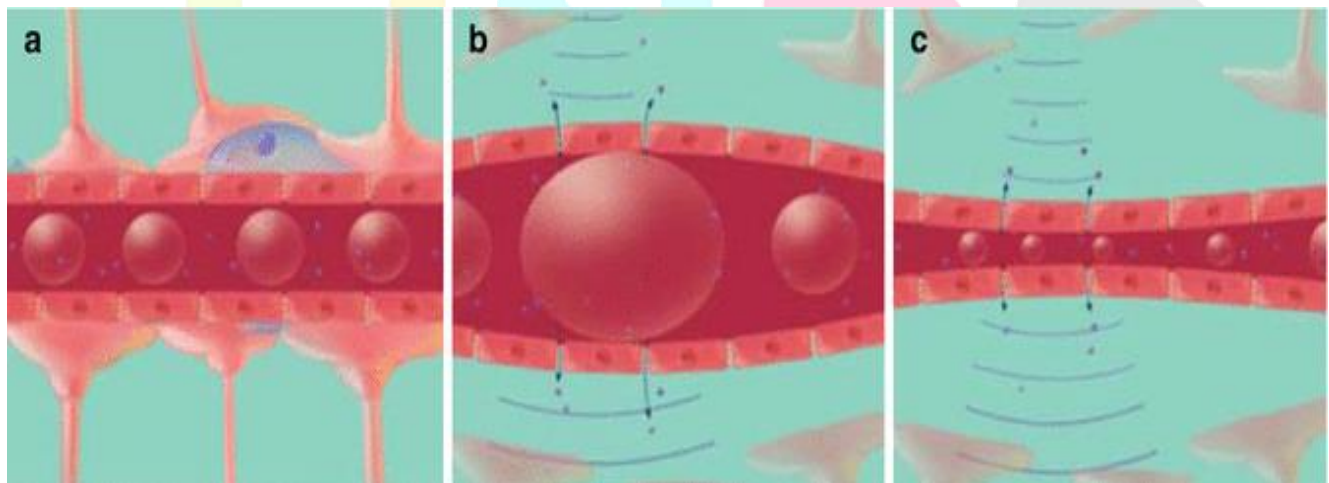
(a) Microbubbles flow through the vasculature. (b) When ultrasound is applied, the microbubbles expand and (c) contract at the frequency of the ultrasound [17]
